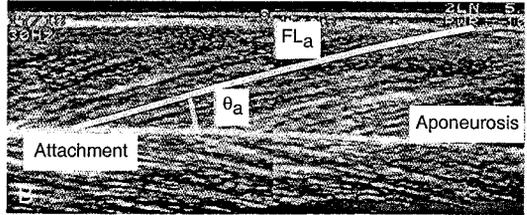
Ultrasound images of human vastus lateralis measured in the sagittal plane with knee at 50° flexion. (A) Muscle image at rest. (B) Muscle image with the quadriceps activated. Muscle activation, even with the knee in a fixed position, results in approximately 7° fiber rotation. Results are even more pronounced as knee angle changes. (Figure adapted from data from Fukunaga T, Ito M, Ichinose Y, et al: Tendinous movement of a human muscle during voluntary contractions determined by real-time ultrasonography. *J Appl Physiol* 8:1430–1433, 1996 and Kawakami Y, Ichinose Y, Fukunaga T: Architecture and functional features of human triceps surae muscles during contraction. *J Appl Physiol* 85:398–404, 1998.)
